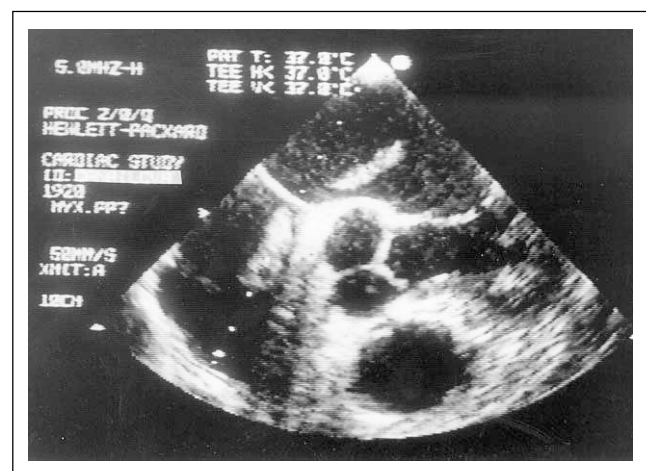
Transesophageal echocardiography: Pseudomyxoma in the right and left atrium
